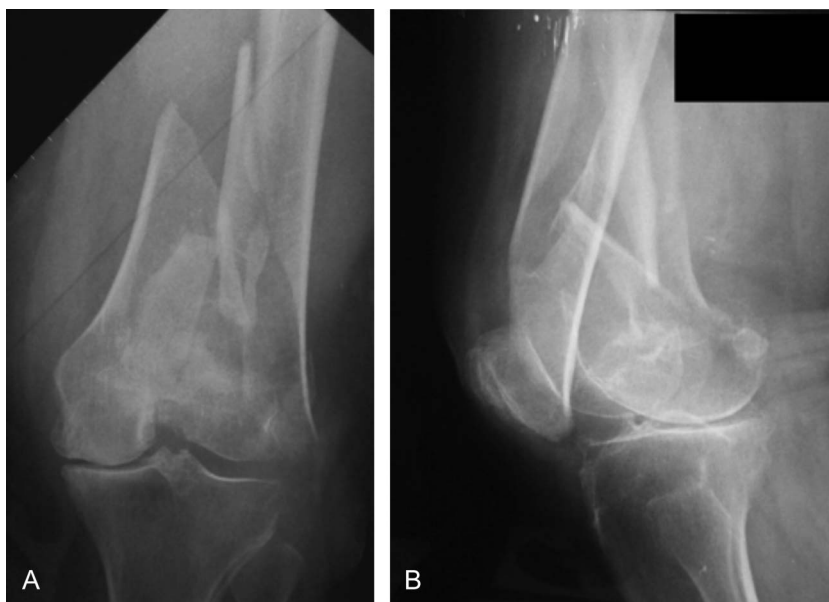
Anteroposterior (A) and lateral (B) radiographs of comminuted, intraarticular distal femoral fracture with degenerative joint disease.
